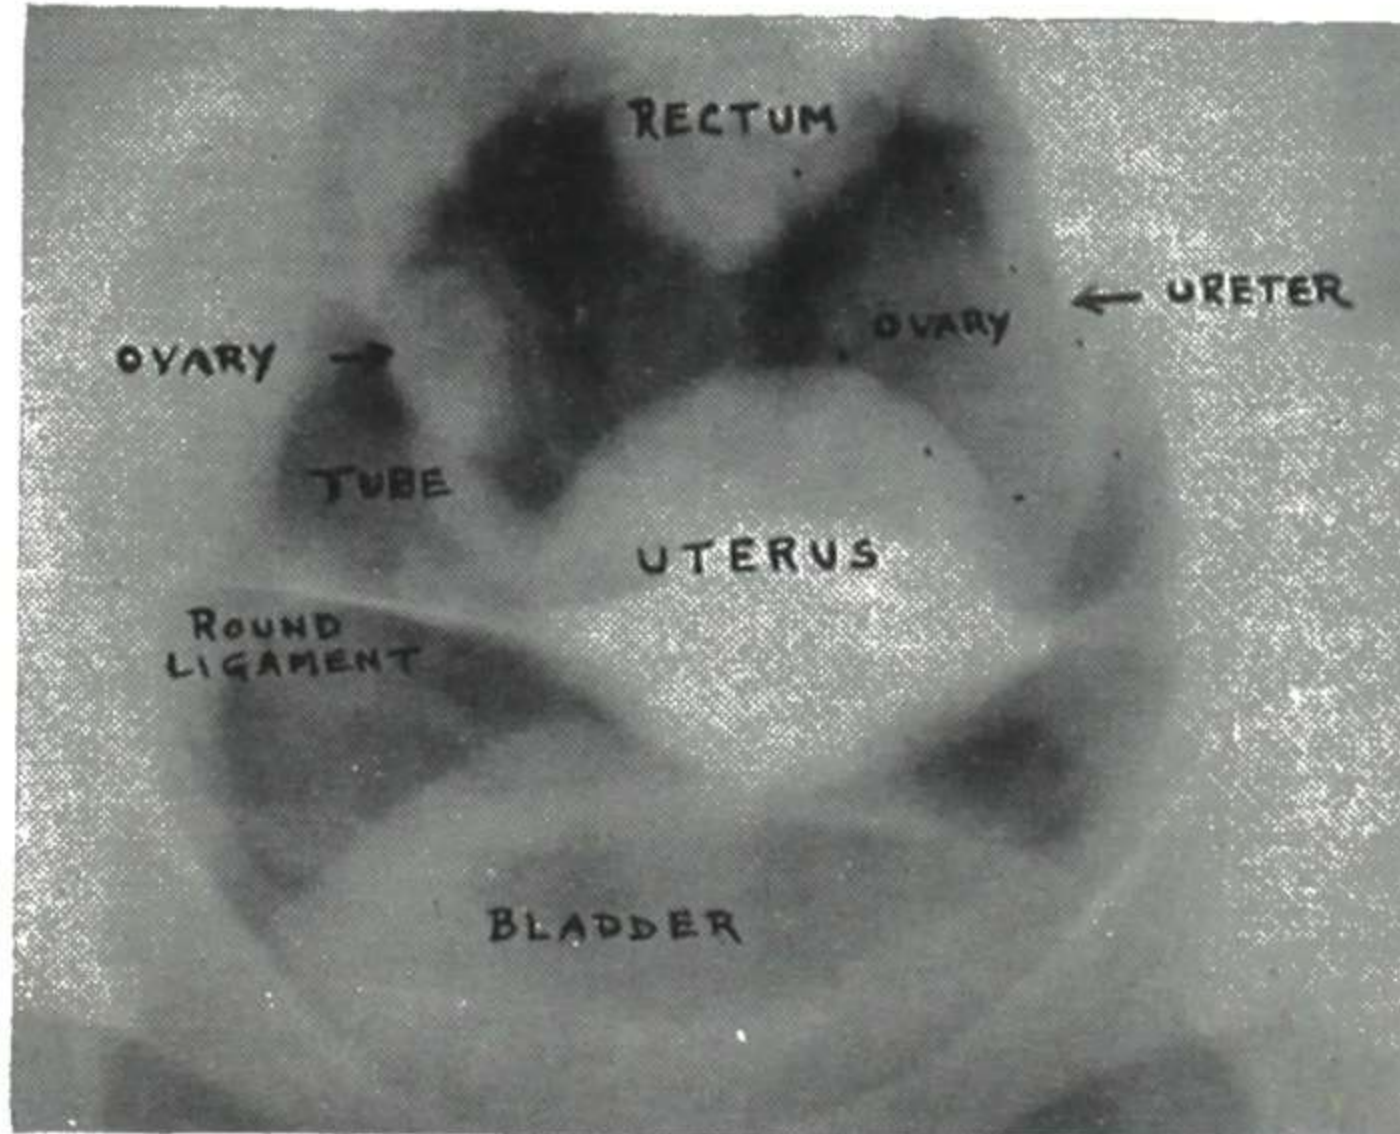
The x-ray appearance of the normal female pelvic organs with pneumoperitonium. (From Gershon-Cohen and Hermel: *Am. J. Obst. & Gynec.*, July, 1952.)
